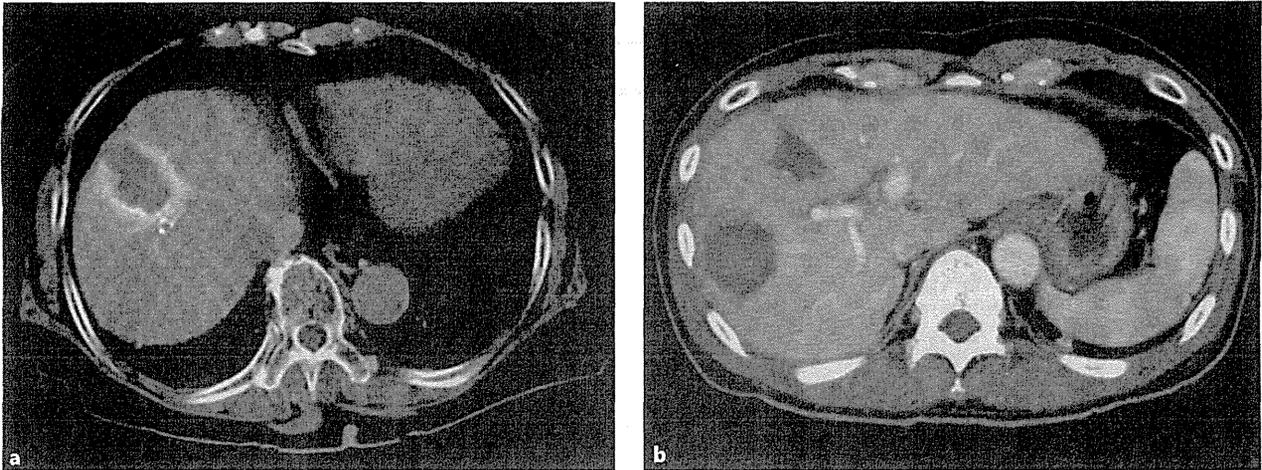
Enhanced CT images of lesions created by RFA using a temperature control (a) and an impedance control method (b).
